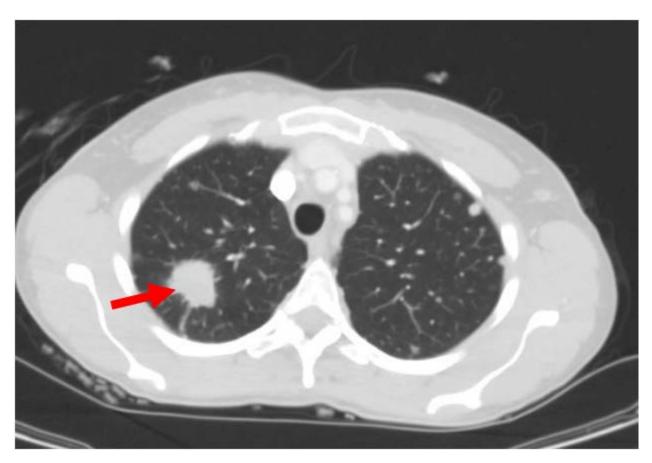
CT of the chest demonstrating a spiculated lung mass in the right upper lobe on axial view
